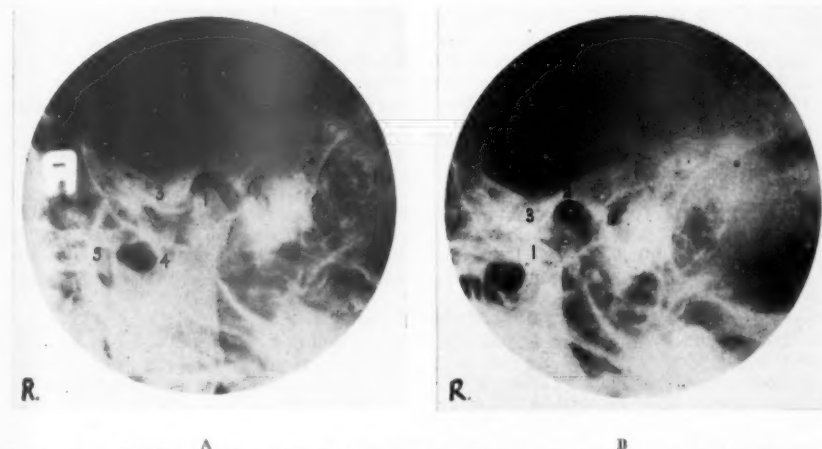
Lateral oblique radiographs of the normal temporomandibular joint. A, closed or at rest. B, open.
